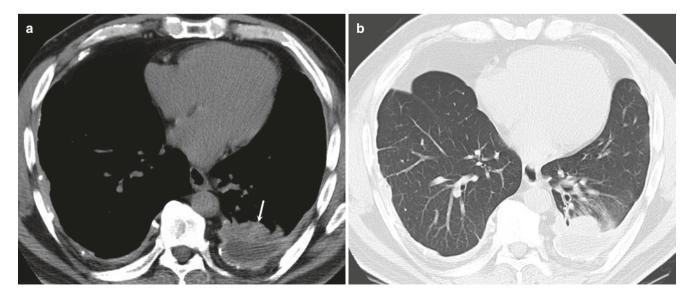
Rounded atelectasis. (a, b) Axial CT images show subpleural opacity (arrow) under chronic pleural effusion with thickened and calcified pleura. Note all criteria for rounded atelectasis are present
